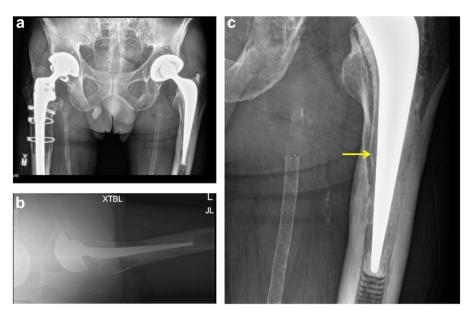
(a) Initial preoperative anterior-posterior (AP) pelvis and (b) cross-table lateral radiographs of the left hip from an outside hospital. An enhanced view of the left hip on the AP view demonstrates a subtle lucency (arrow) that represents a cracked femoral stem.
